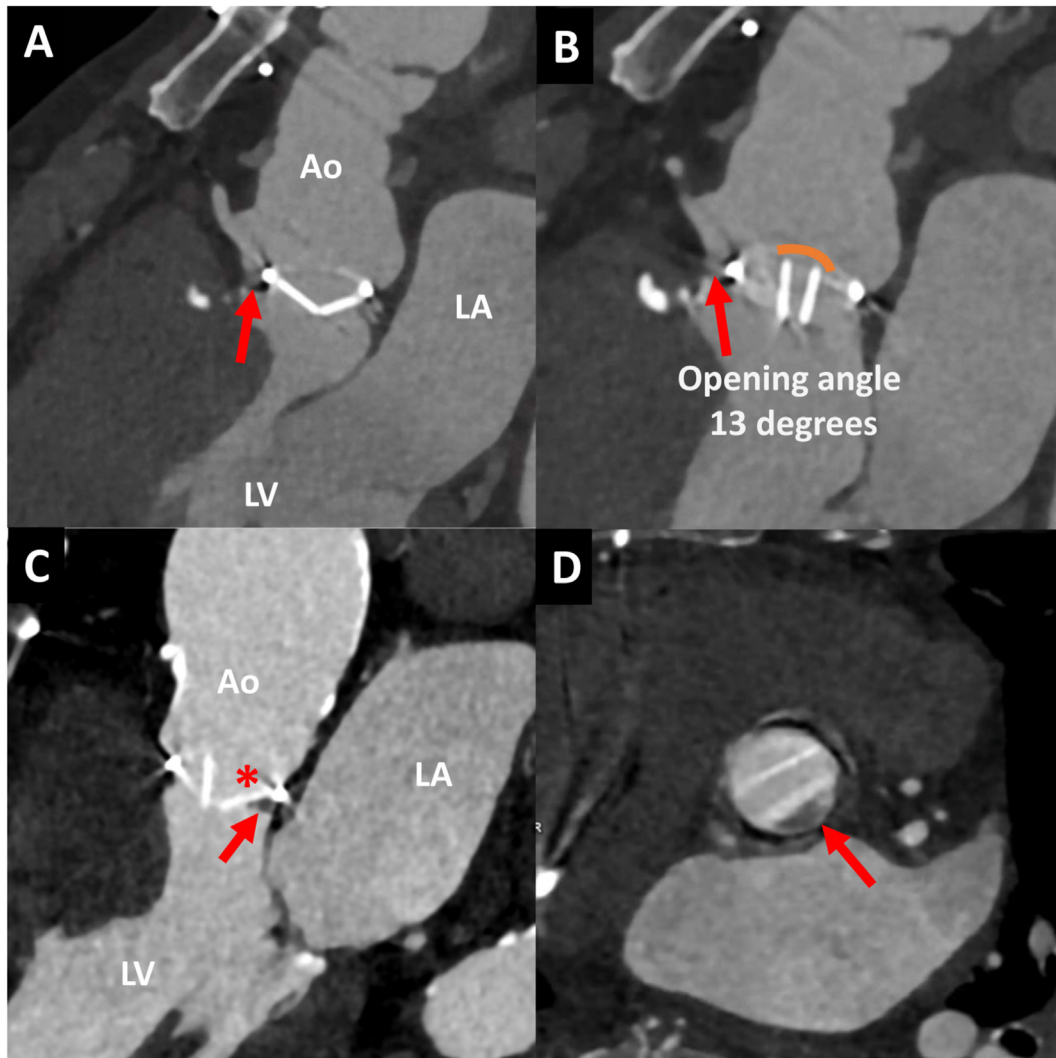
Two cases of bileaflet mechanical aortic valves imaged with cardiac computed tomographic angiography. Case 1 of a patient after the Bentall procedure (*top panels*) shows the aortic valve in diastole (A) and systole (B) with normal closure and opening angles. However, there is an anterior paravalvular dehiscence (*red arrows*). In case 2 (*bottom panels*), three-chamber and short-axis views show a frozen disk of the mechanical aortic valve (*asterisk*) imaged in systole (C). Pannus is seen over the left coronary cusp (*arrow*) in long-axis (C) and short-axis (D) views, with Hounsfield units of 150. Ao, Aorta; LA, left atrium; LV, left ventricle.
